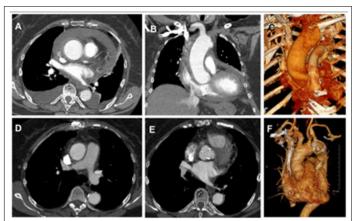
(A-C)Acute aortic dissection with thrombosed false lumen; portal of entry at the distal portion of the ascending aorta. (D-F) Post-surgery CT scan showing supra-coronary tube graft and aortic bioprosthesis.
